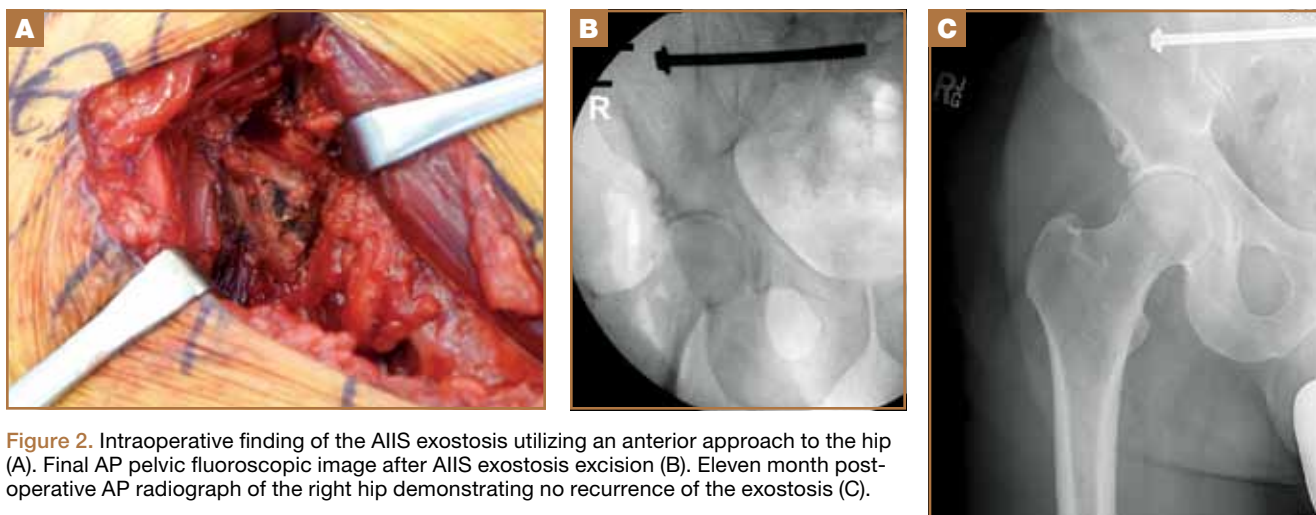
Intraoperative finding of the AIIS exostosis utilizing an anterior approach to the hip (A). Final AP pelvic fluoroscopic image after AIIS exostosis excision (B). Eleven month post-operative AP radiograph of the right hip demonstrating no recurrence of the exostosis (C).
